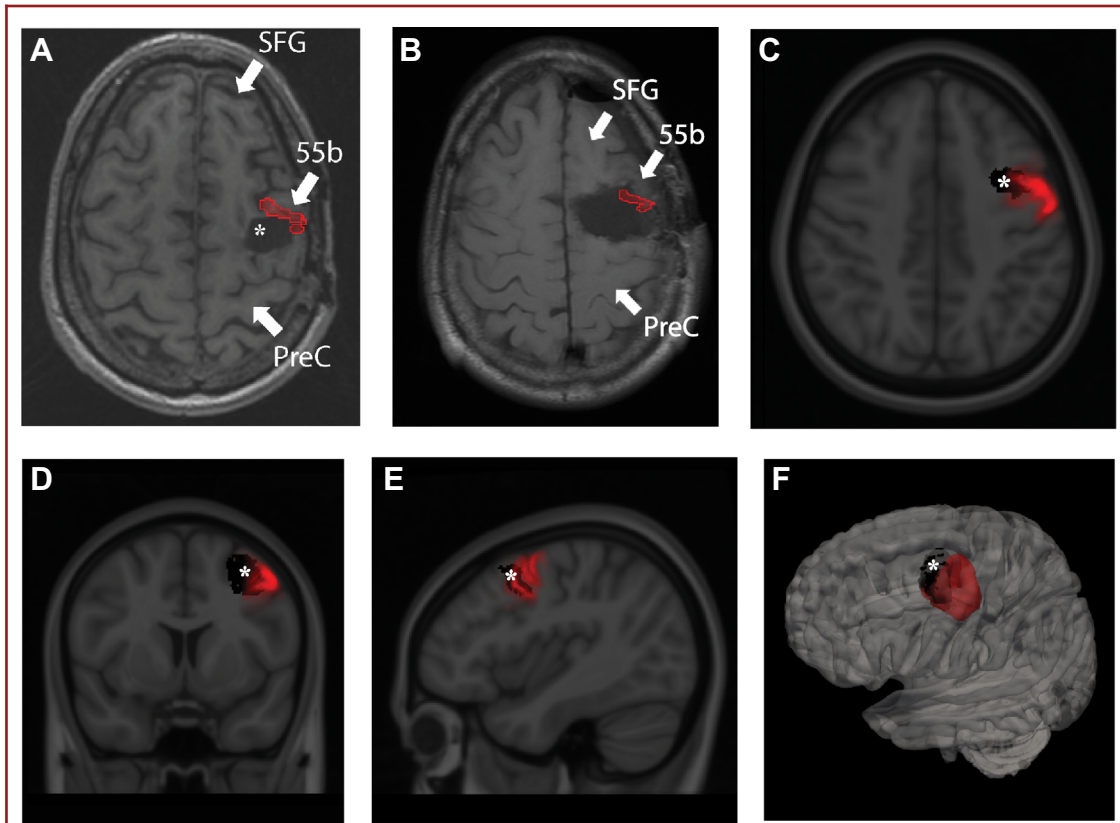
A, Area 55b projected onto axial MRI of the patient prior to the resection causing his AOS. Asterix marks the first resection cavity sparing Area 55b (corresponding to the panel of Figure 1 labelled “initial resection”), which did not cause language deficits. B, Area 55b projected onto the cavity after the resection, which led to AOS deficits. C, Axial, D, coronal, and E, sagittal cuts of the MNI brain co-registered with probability maps of Area 55b (Red) and the defect prior to AOS-causing resection (black). F, 3D reconstruction with the probability map of Area 55b depicted in red and the defect prior to AOS-causing resection (black). SFG = Superior frontal gyrus; 55b = Area 55b; PreC = Pre-central gyrus; * = original resection cavity prior to AOS-causing resection.
